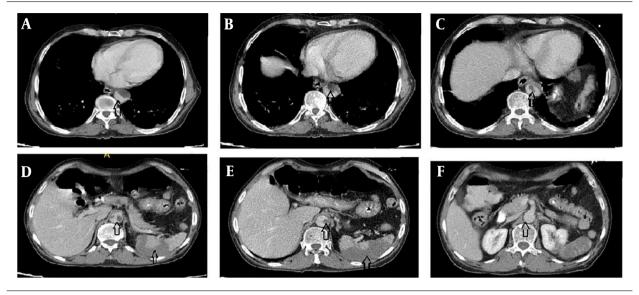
Spiral abdominal and pelvic CT scans of the patient
